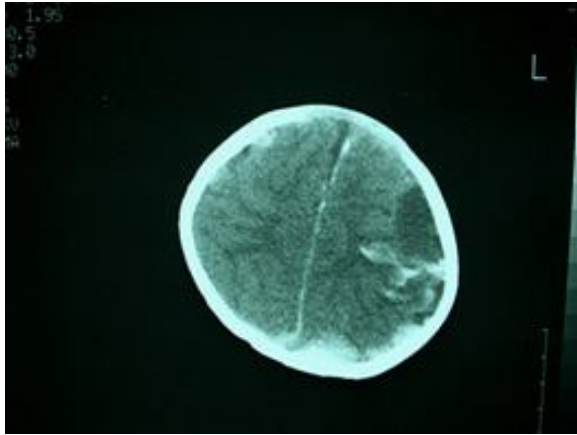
Cranial CT scan of a patient with intraparenchymal, subdural and subarachnoid hemorrhage.
